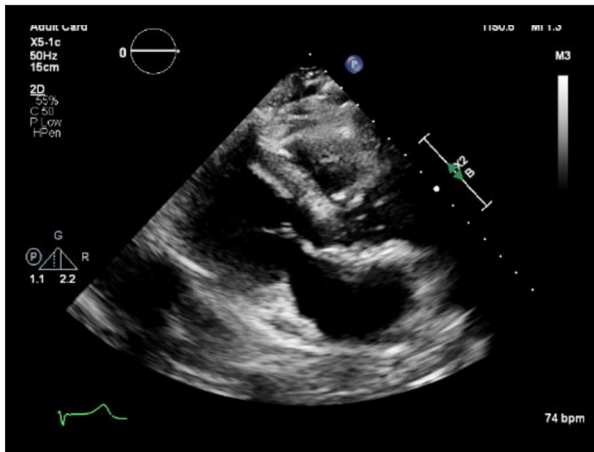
Contrast-enhanced echocardiogram. Contrast-enhanced transthoracic echocardiogram showing severe hypokinesis and akinesis of the basal-to-mid left ventricular segments with preserved apical contraction, consistent with reverse takotsubo cardiomyopathy.
